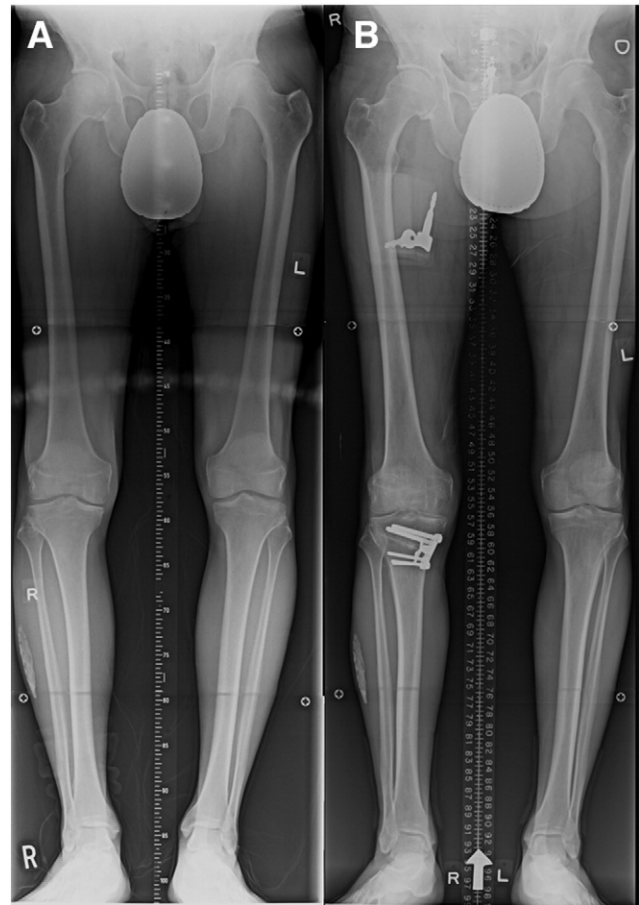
Full leg radiographs before (A) and after (B) medial opening wedge high tibial osteotomy.
